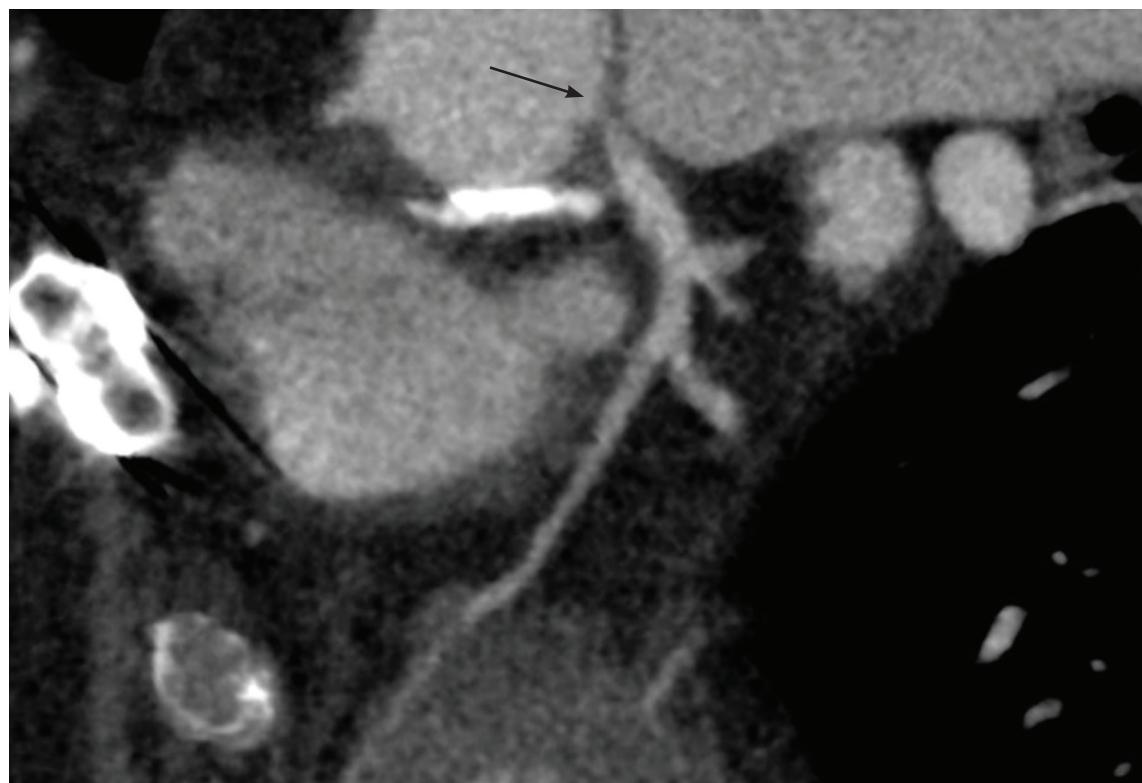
Computed tomography coronary angiography using multiplanar reconstruction reveals a critical ostial left main stenosis.
